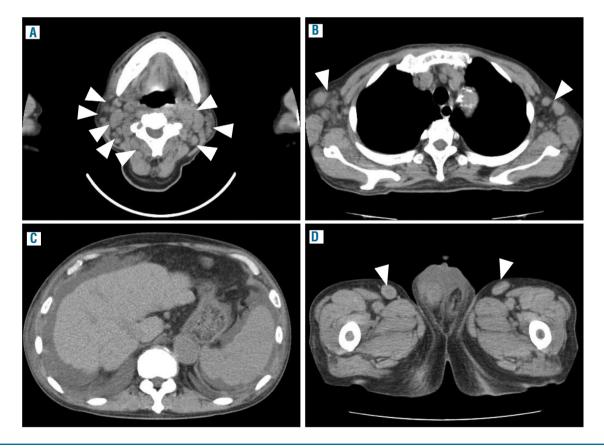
Computed tomography (CT). A CT scan showed generalized lymphadenopathy, shown by arrowheads, in the cervical lymph nodes (LNs) (A), axillary LNs (B), and inguinal LNs (D); and splenomegaly with moderate ascites (C).
